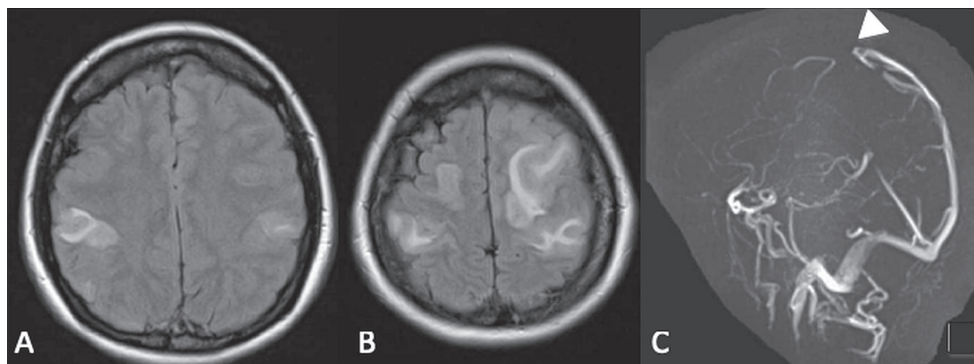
Brain magnetic resonance FLAIR sequence demonstrates bilateral frontoparietal edema (A, B) and magnetic resonance venography reveals an occlusion in the middle third of the superior sagittal sinus (arrowhead) on admission.
